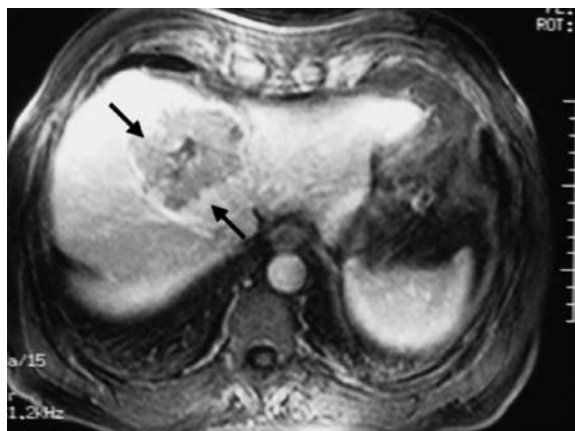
Axial, venous phase, gadolinium-enhanced MRI of a patient with unresectable HCC showing a peripherally enhanced lesion (arrows) in the medial segment of the left lobe. Solid, well demarcated lesions such as this one respond better to TACE than do diffuse or multifocal lesions. Additionally, hypervascular tumors appear to respond better to TACE showing a higher degree of necrosis on follow-up MRI
